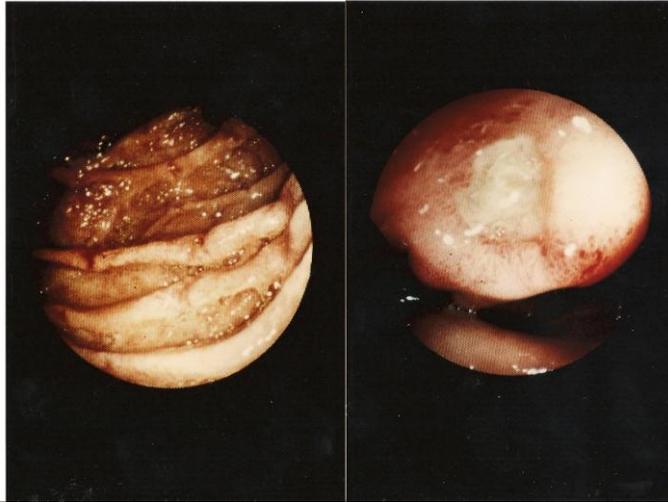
These are stellate-shaped, serpiginous or deep, and may give a cobblestone appearance on barium x-rays.
